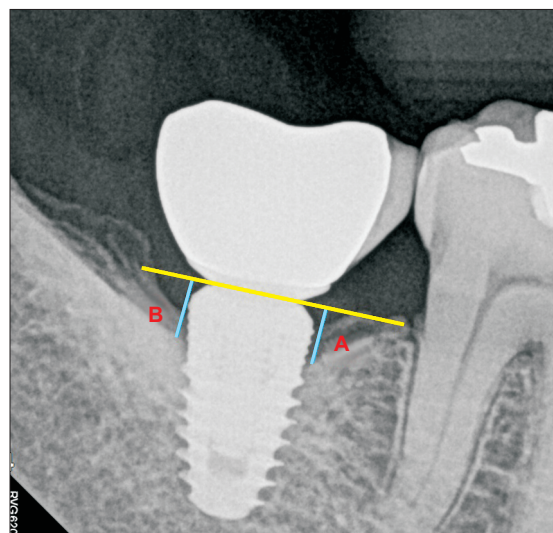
Landmarks of the radiographic measurements. A point: Linear distance from implant shoulder to contact point of implant and bone (mesial surface), B point: Linear distance from implant shoulder to contact point of implant and bone (distal surface). The mean value of A point and B point was set as the marginal bone resorption amount.
